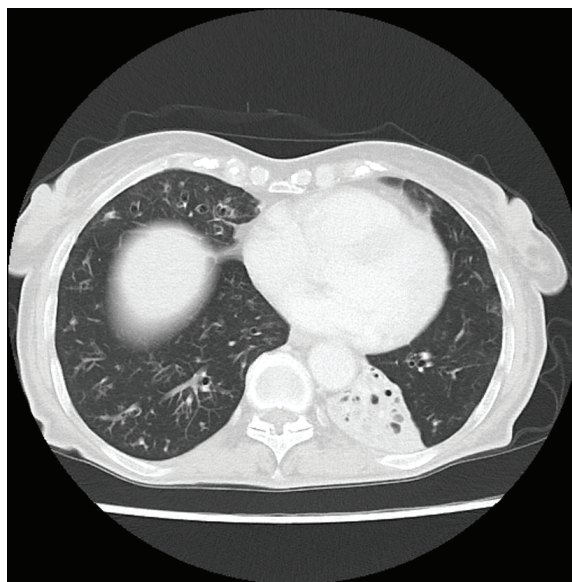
Chest CT-scan demonstrates left lower lobe atelectasis and multiple foci of bronchiectasis.
